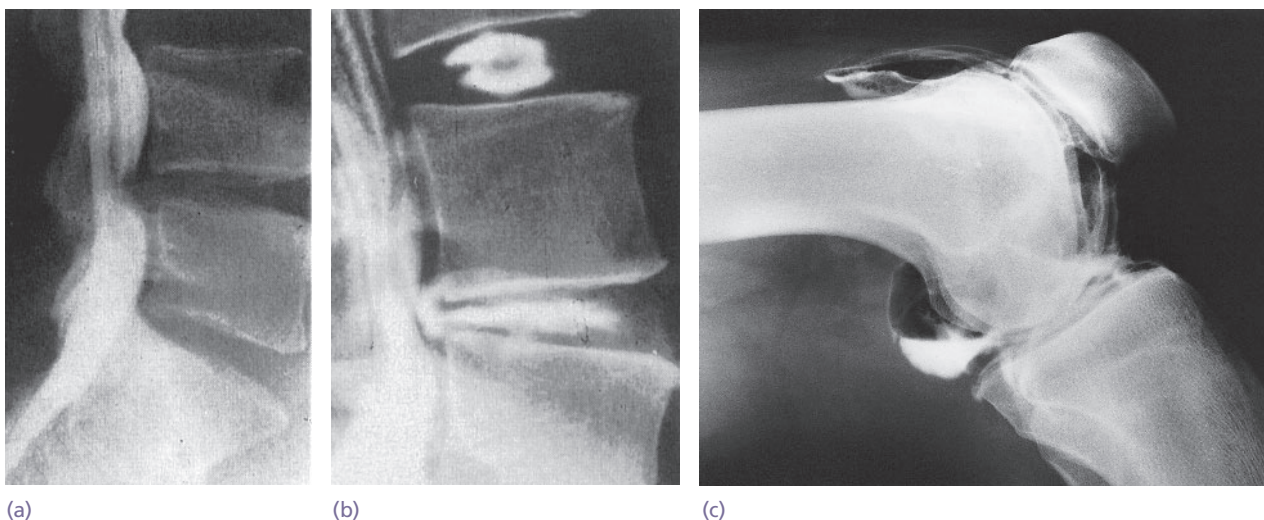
Contrast radiography (a) Myelography shows the outline of the spinal theca. Where facilities are available, myelography has been largely replaced by CT and MRI. (b) Discography is sometimes useful: note the difference between a normal intervertebral disc (upper level) and a degenerate disc (lower level). (c) Contrast arthrography of the knee shows a small popliteal herniation.
